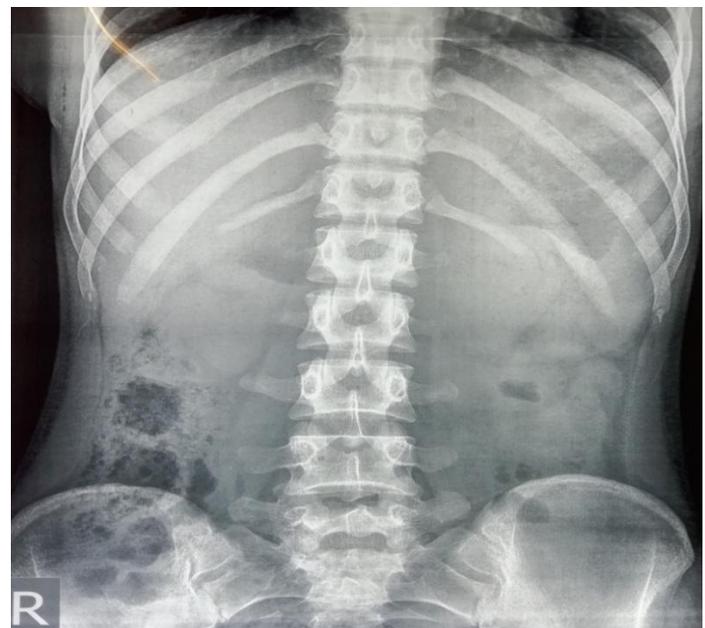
Plain X-ray erect abdomen taken after intervention showing complete evacuation of all types of metallic foreign bodies from the GIT
